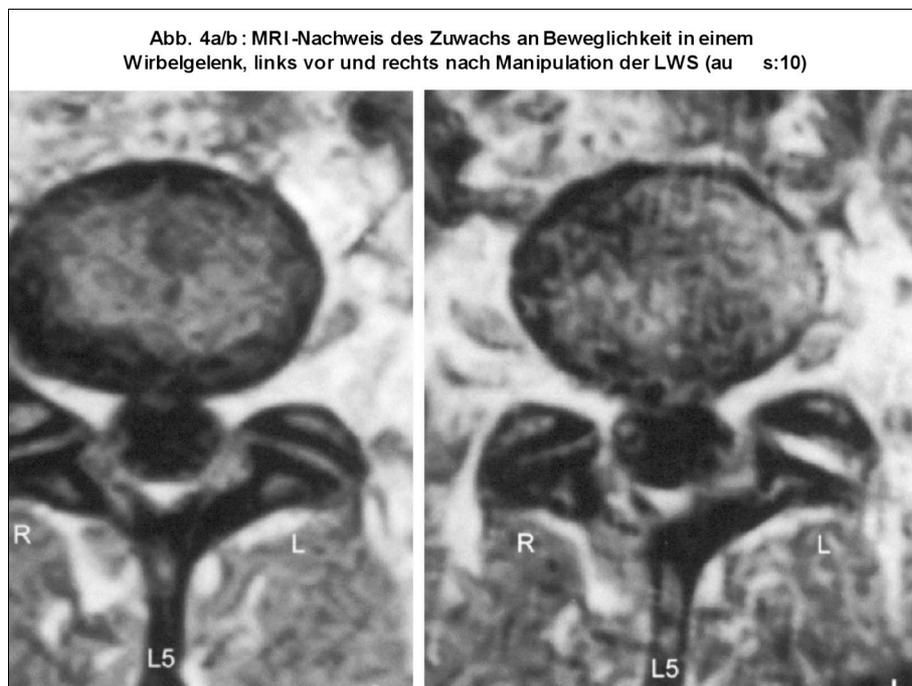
/bc: MRI-based evidence of increased mobility of a vertebral joint, left prior and right following manipulation of the lumbar spine¹⁰.
